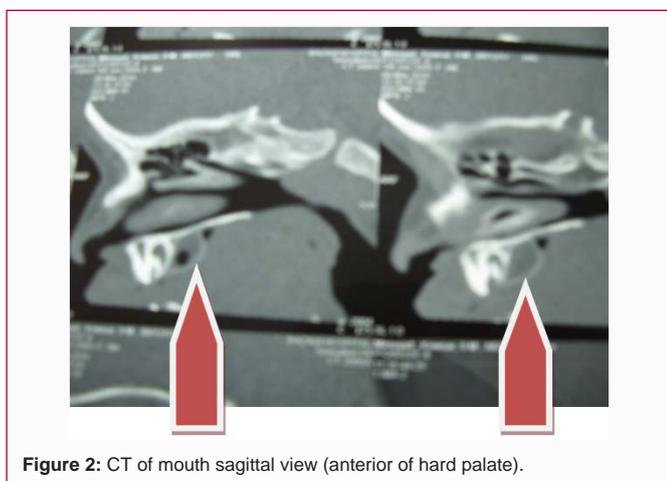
CT of mouth sagittal view (anterior of hard palate).
